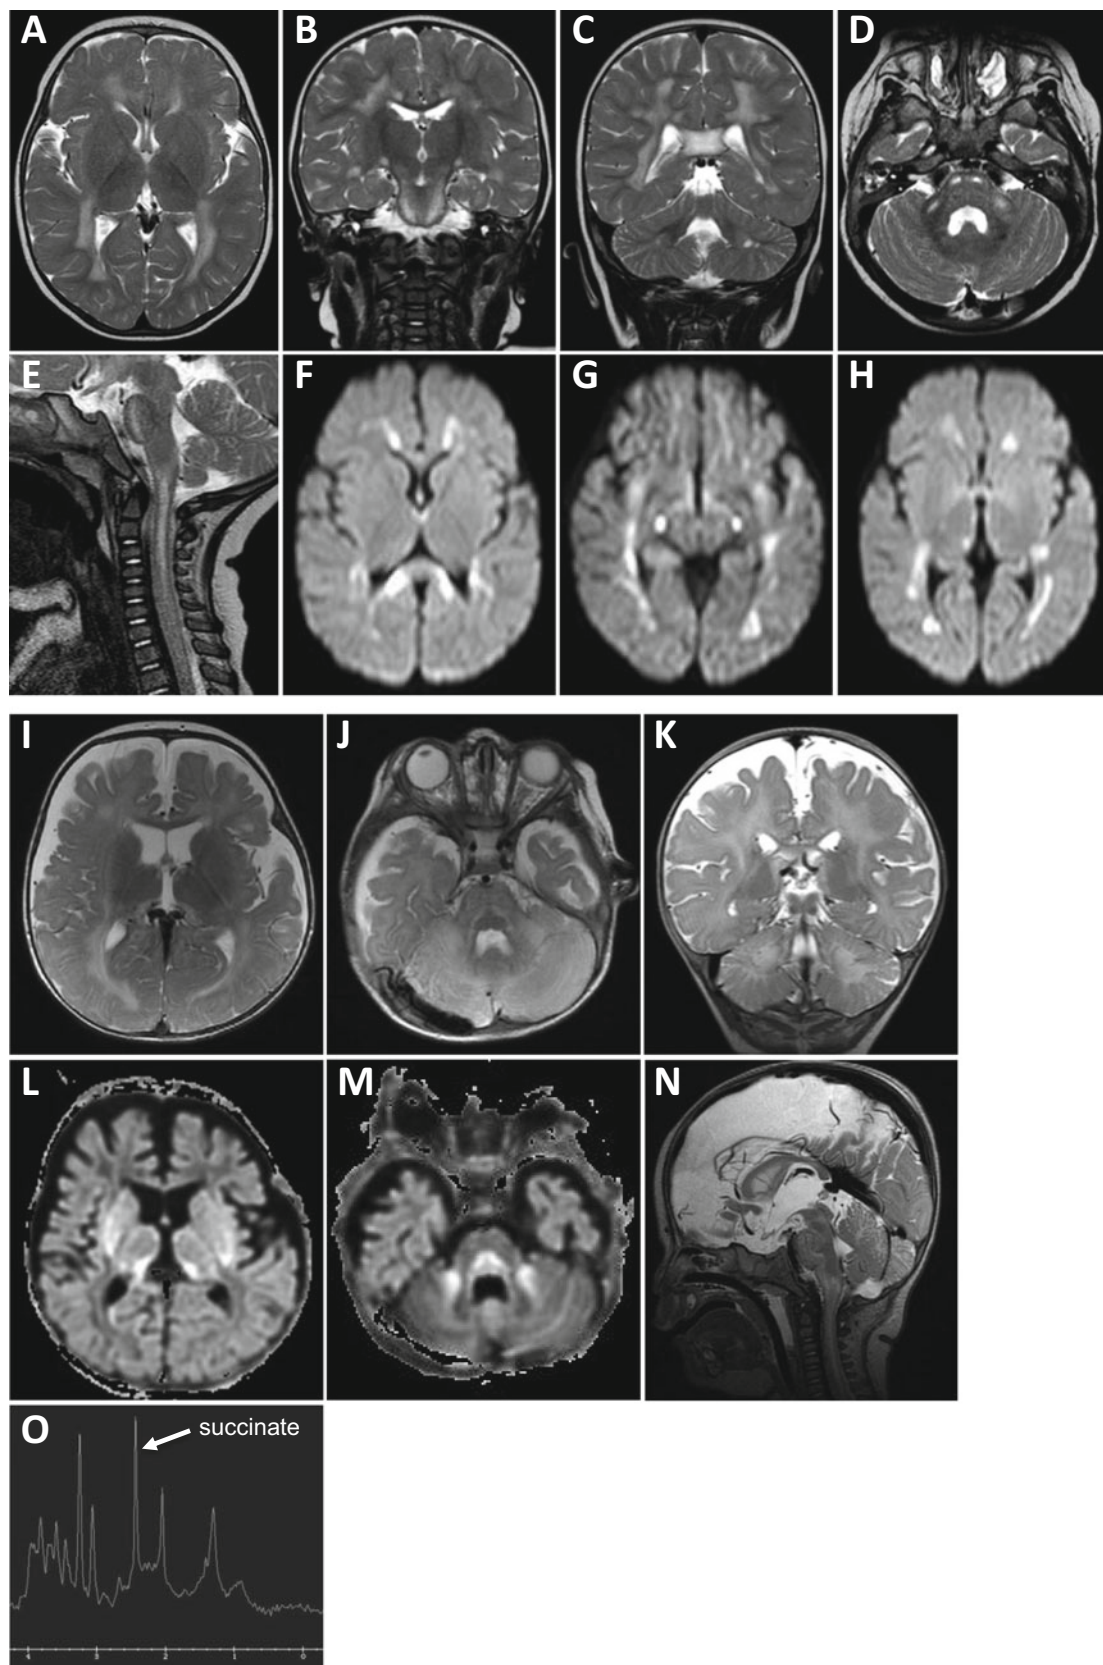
Magnetic resonance imaging (MRI) of patient 1 (a–h) at 15 months of age and patient 2 (i–n) at 10 months of age including
